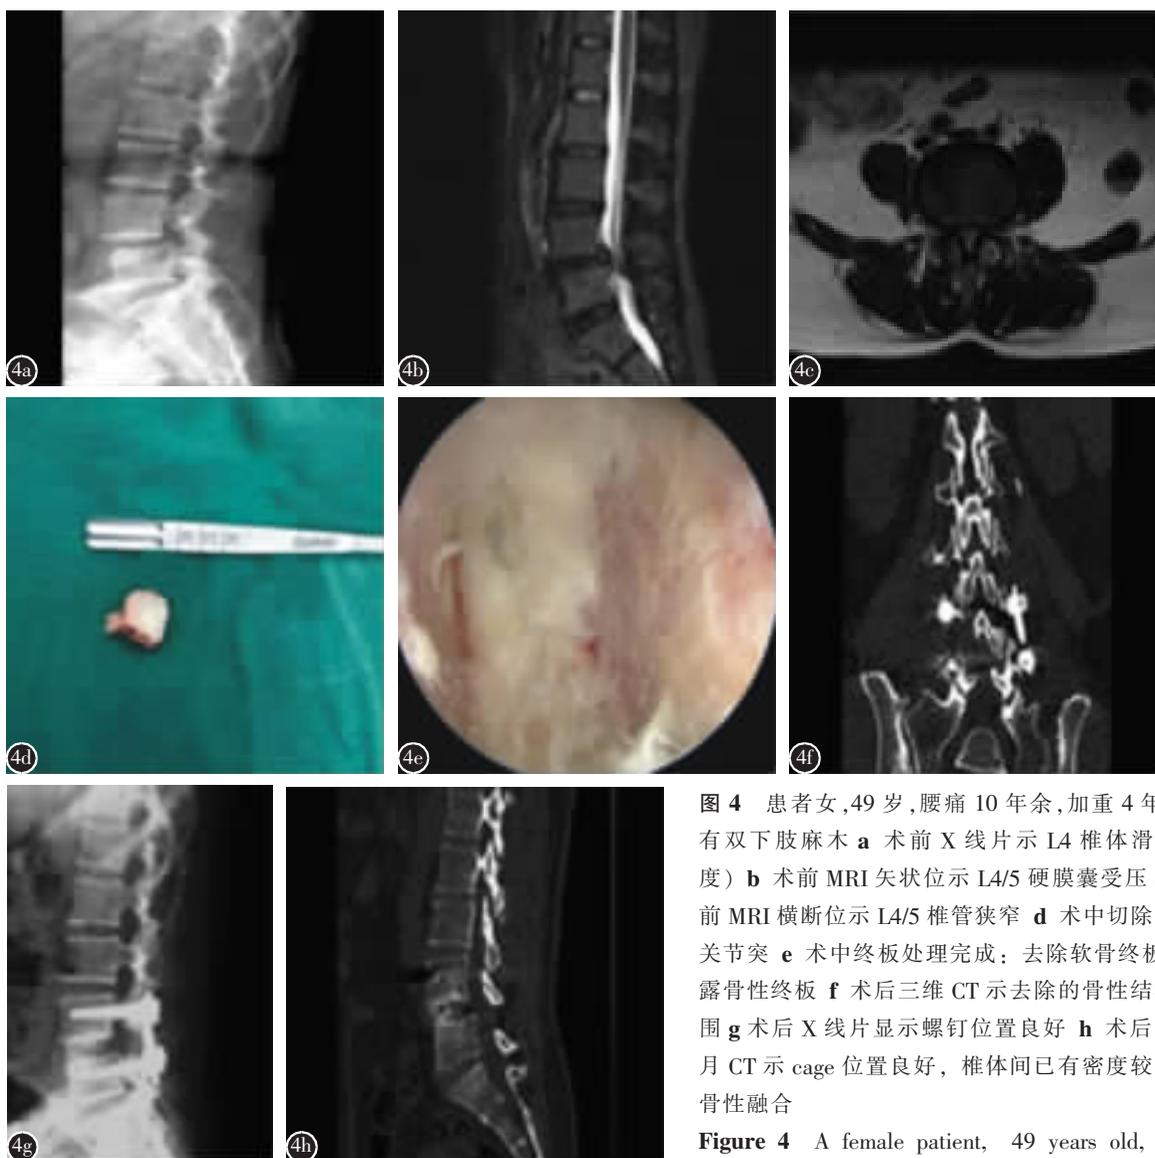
患者女,49 岁,腰痛 10 年余,加重 4 年,伴有双下肢麻木 a 术前 X 线片示 L4 椎体滑脱(I 度) b 术前 MRI 矢状位示 L4/5 硬膜囊受压 c 术前 MRI 横断位示 L4/5 椎管狭窄 d 术中切除的下关节突 e 术中终板处理完成:去除软骨终板,显露骨性终板 f 术后三维 CT 示去除的骨性结构范围 g 术后 X 线片显示螺钉位置良好 h 术后 6 个月 CT 示 cage 位置良好,椎体间已有密度较高的骨性融合
